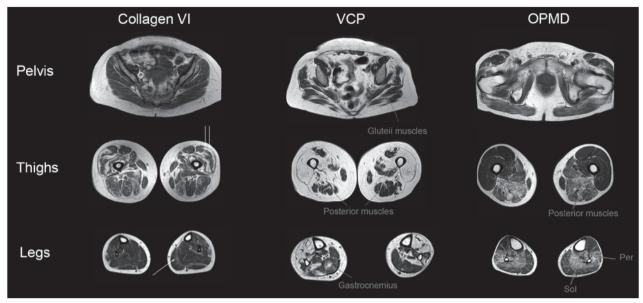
Muscle MRI of patients with collagen VI related myopathy, HIBMPD and OPMD muscle dystrophies. A: Muscle MRI of a 20 years old patient with mutations in the COL6A3 gene showing concentric atrophy of the vastus lateralis (double arrow) and a band of atrophy between gastrocnemius medialis and soleus (single arrow). B: Muscle MRI of a 56 years old woman with a mutation in the VCP gene producing patchy atrophy of the glutei, posterior muscles of the thighs and both gastrocnemius. C: Muscle MRI of a 72 years old patient with OPMD showing preferential involvement of posterior muscles of the thighs and the soleus muscle.
